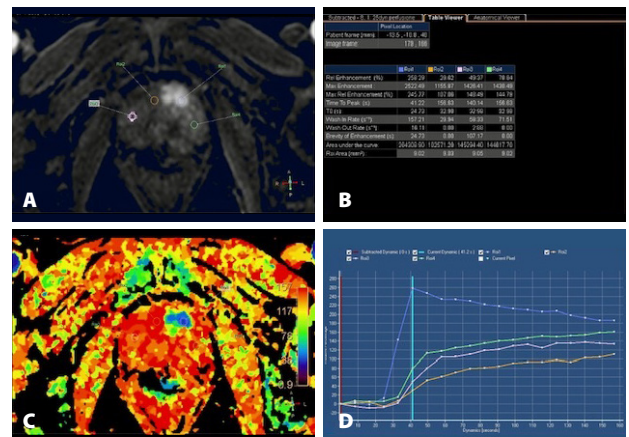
Postprocessing dynamic contrast enhanced MR images. Axial plane with 4 regions of interest positioned (A), table viewer (B), axial plane colored map of quantification (C), and peak improvement graph (D). Images courtesy of the author.
